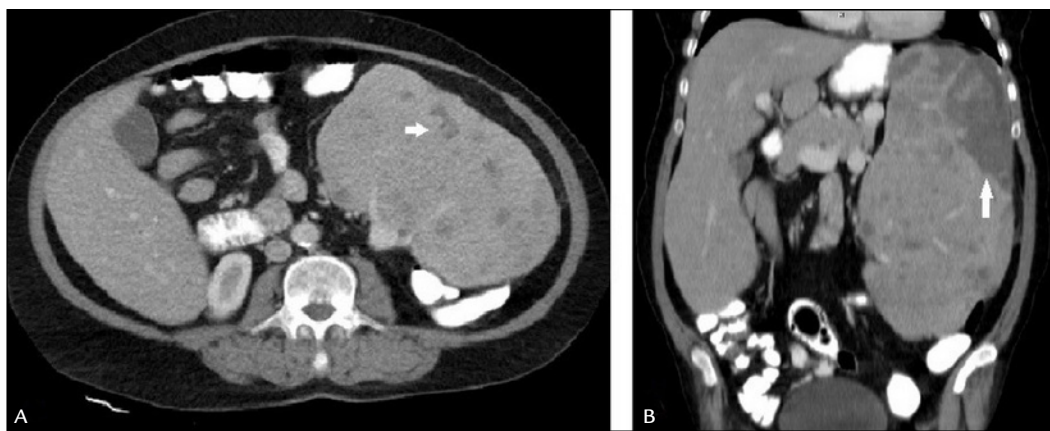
Hepatosplenomegaly, splenic nodules (A) and splenic infarct (B) at abdominal CT.
